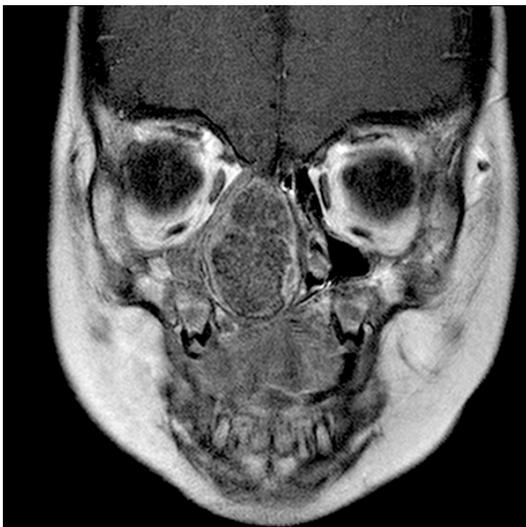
Coronal contrast-enhanced T1-weighted MRI demonstrates heterogeneously enhancing intranasal mass filling the right nasal cavity. The mass is displacing the nasal septum. A huge mass filled total right nasal cavity, displaced the nasal septum, and extended to the right cribriform plate superiorly and palate inferiorly. Posterior choana was nearly obstructed. There is no intracranial extension.
